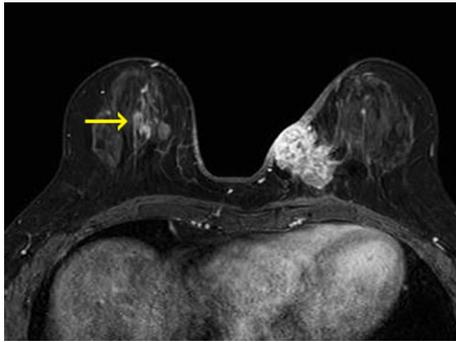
A 63-year-old woman with cancer in the left breast. MRI reveals segmental non-mass enhancement (arrow) in the contralateral right breast that was not visible using mammography and ultrasonography
